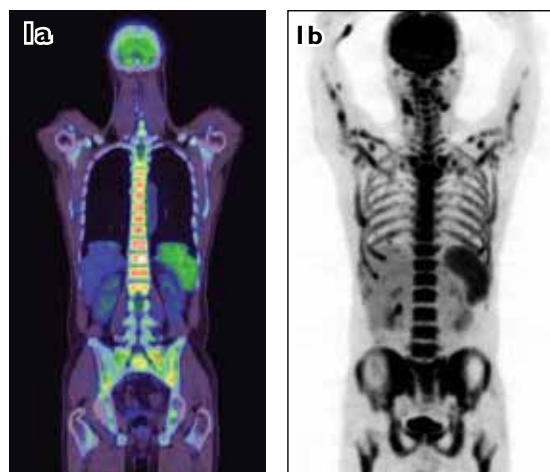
(a) PET/CT and (b) maximum intensity projection (MIP) images show diffuse lymphomatous involvement of the bone marrow in Case 1.
